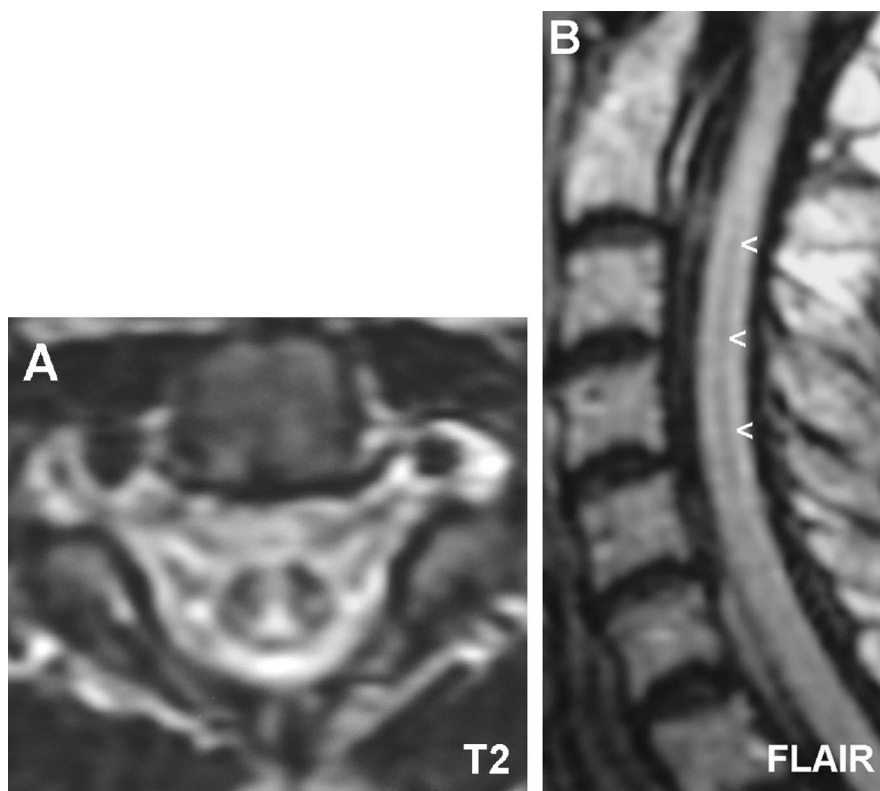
Cervical MRI upon admission: central spinal cord signal abnormalities, hyperintense in T2-weighted (A) and hypointense in T1-weighted and in fluid-attenuated inversion recovery (FLAIR) images (B), compatible with a hydromyelia. It coexisted with T2-weighted hyperintensities of the posterior, lateral, and anterior columns and completely remitted with vitamin B12 treatment.
